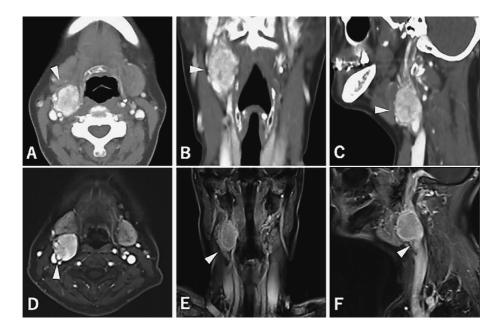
Preoperative CT/MRI findings. A, B, C, Preoperative contrast-enhanced CT images demonstrating a mass with contrast enhancement at the carotid bifurcation (arrowhead); D, E, F, Preoperative contrast-enhanced MRI images showing a well-defined border between the mass and the internal jugular vein, but with signal loss at the interface with the carotid artery wall (arrowhead). CT, computed tomography; MRI, magnetic resonance imaging.
